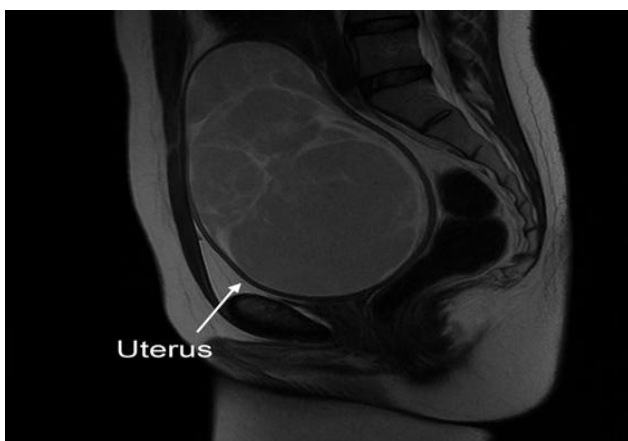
MRI of ovarian mass.
